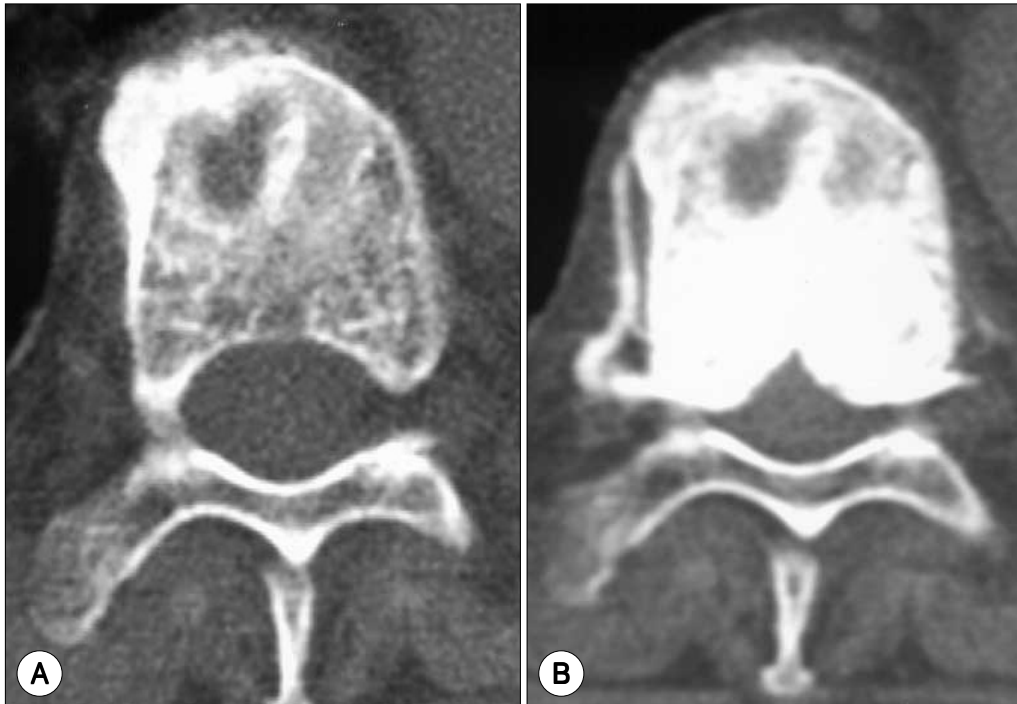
A : Axial CT scan showing wedge compression fracture of vertebral body with double-contoured margin of the body. B : Postoperative CT scan at the same level showing epidural leak of PMMA through the basivertebral foramina into the intervertebral foramen as well as the spinal canal
